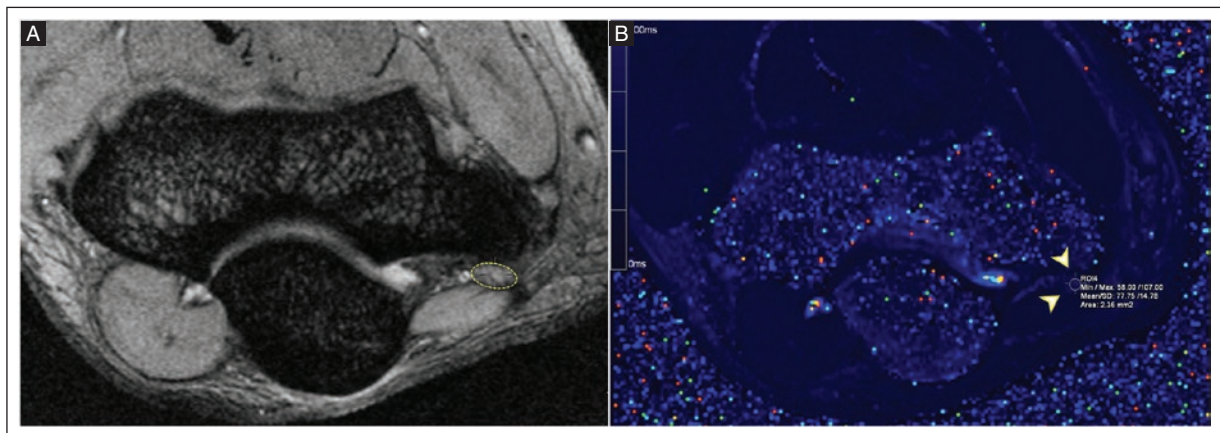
Axial MRI at the level of the cubital tunnel. A: T2 relaxometry multi-echo sequence (TR = 2400 ms; TE = 12 ms) shows homogeneous hyperintensity with normal appearing hypointense fascicles of the ulnar nerve (yellow dashed circle). B: T2 relaxometry color map with ROI of 2.36 mm² in the ulnar nerve with a T2 relaxation time mean of 77.75 ms (yellow arrowheads).
